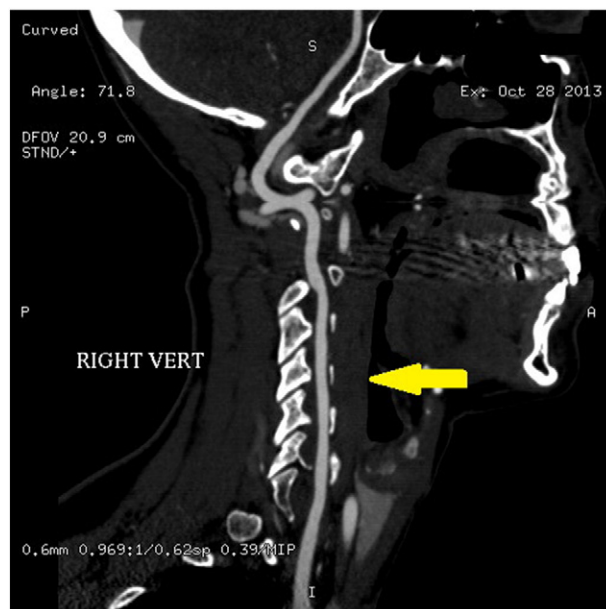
CT angiography neck image. Curved planar reformatted imaging of the right vertebral artery from CT angiography of the neck performed three months after initial imaging reveal near complete resolution of the right vertebral artery narrowing related to arterial dissection. (Color version of figure appears online.)
